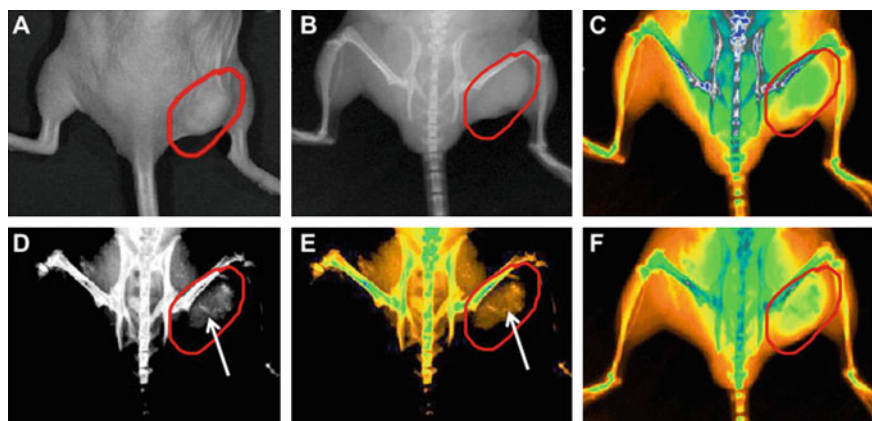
Real-time in vivo X-ray images. a The tumor tissue, b X-ray image at 0 h, c X-ray image at 0 h (in color), d X-ray image at 12 h, e X-ray image at 12 h (in color). f X-ray image at 24 h (in color). Reproduced with permission from Ref. [41]. Copyright 2011, with permission from Elsevier
